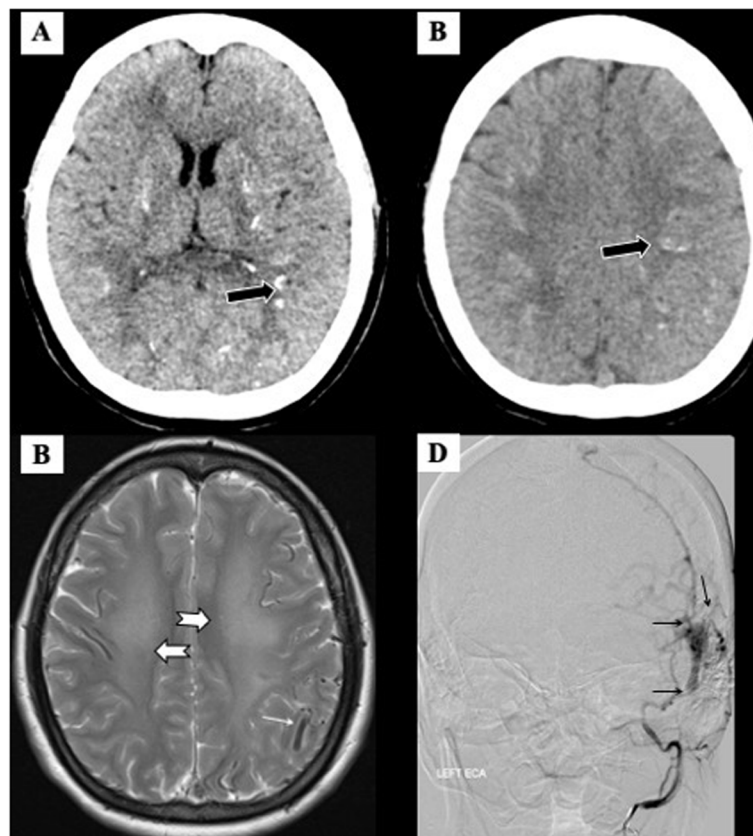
a, b Axial NCECT brain shows subcortical calcification (black arrows). c Axial T2W MRI brain shows white matter hyperintensity (large white arrows) and dilated veins (small white arrow). d DSA of left ECA image in coronal view shows multiple abnormal communication between ECA branches and left sigmoid sinus dural AVF (small black arrows)
